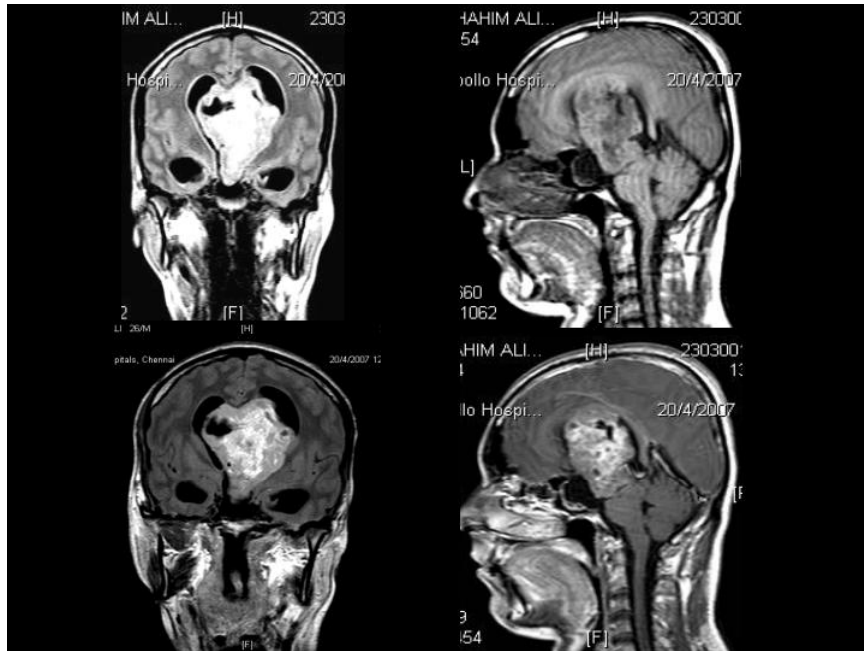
MRI shows, a large, midline, solid with cystic areas, intensely enhancing septal mass causing obstructive hydrocephalus-high grade neoplasm
